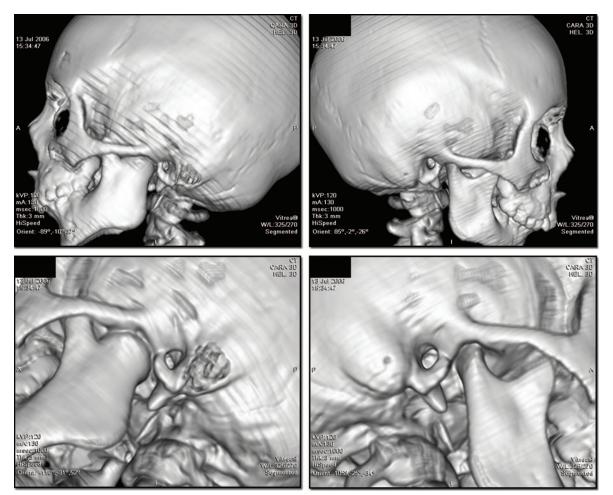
Case 1. Three-dimensional reconstructed computed tomographic scan of a boy (patient 24) who developed left temporomandibular joint ankylosis following trauma at 3 years of age. Findings include a shortened, widened condyle that is fused to the cranial base. The left coronoid process is hypertrophic. In contrast, the right temporomandibular joint is normal.
